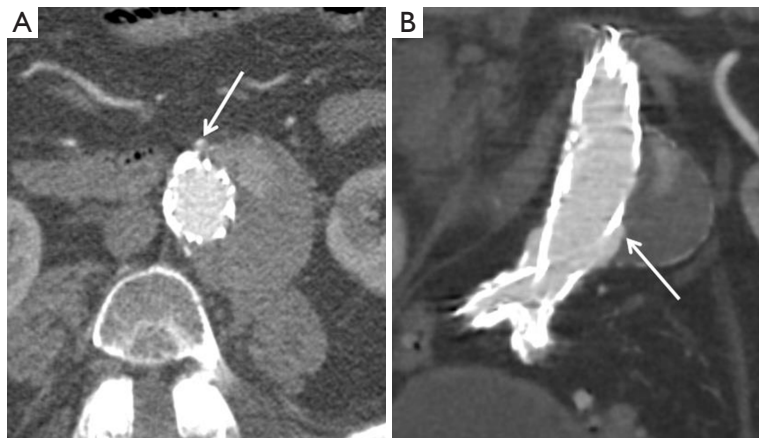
A 91-year-old man with type II endoleak. (A) Axial CT angiogram demonstrates small contrast material outside the stent-graft at the level of proximal neck of infrarenal abdominal aortic aneurysm, arising from patent IMA (arrow); (B) coronal reformatted CT angiogram shows contrast material (arrow) outside the stent-graft, but within the aneurysm sac. IMA, inferior mesenteric artery.
